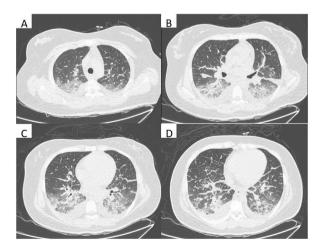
Chest CT scans at different levels showed exudative lesions.
